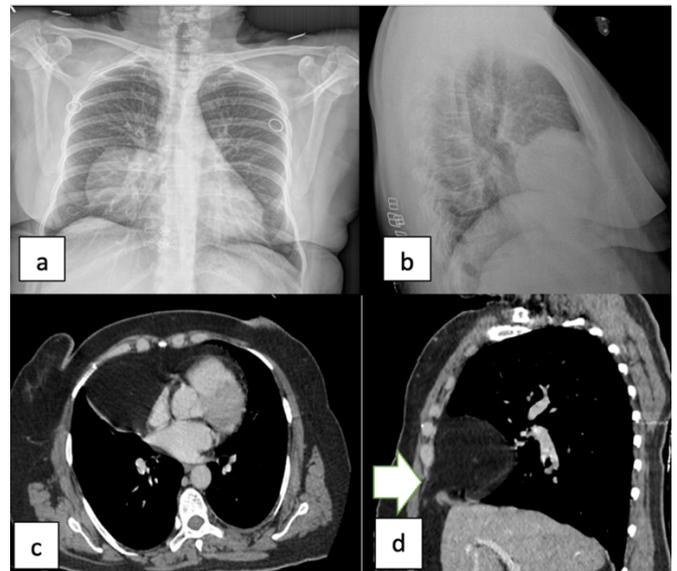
(a). Posteroanterior chest X-ray in a 48-year-old woman with Morgagni's hernia, shows a round right pericardiophrenic density. (b) Lateral chest radiograph localizes the opacity to the retrosternal area. (c) Axial computed tomographic scan showing a right retrosternal hernia containing omentum in the anterior cardiophrenic angle. (d) Sagittal computed tomographic scan showing the diaphragmatic defect (arrow).
